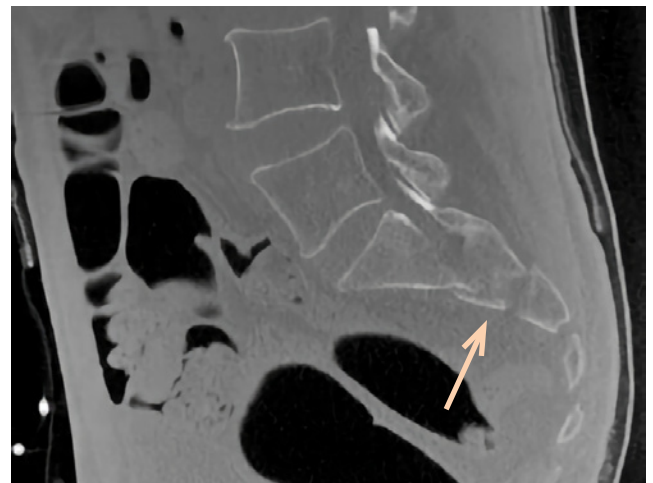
Sagittal CT scan demonstrating transverse component at the junction of S1 and S2 making this a sacral U-type of fracture.
